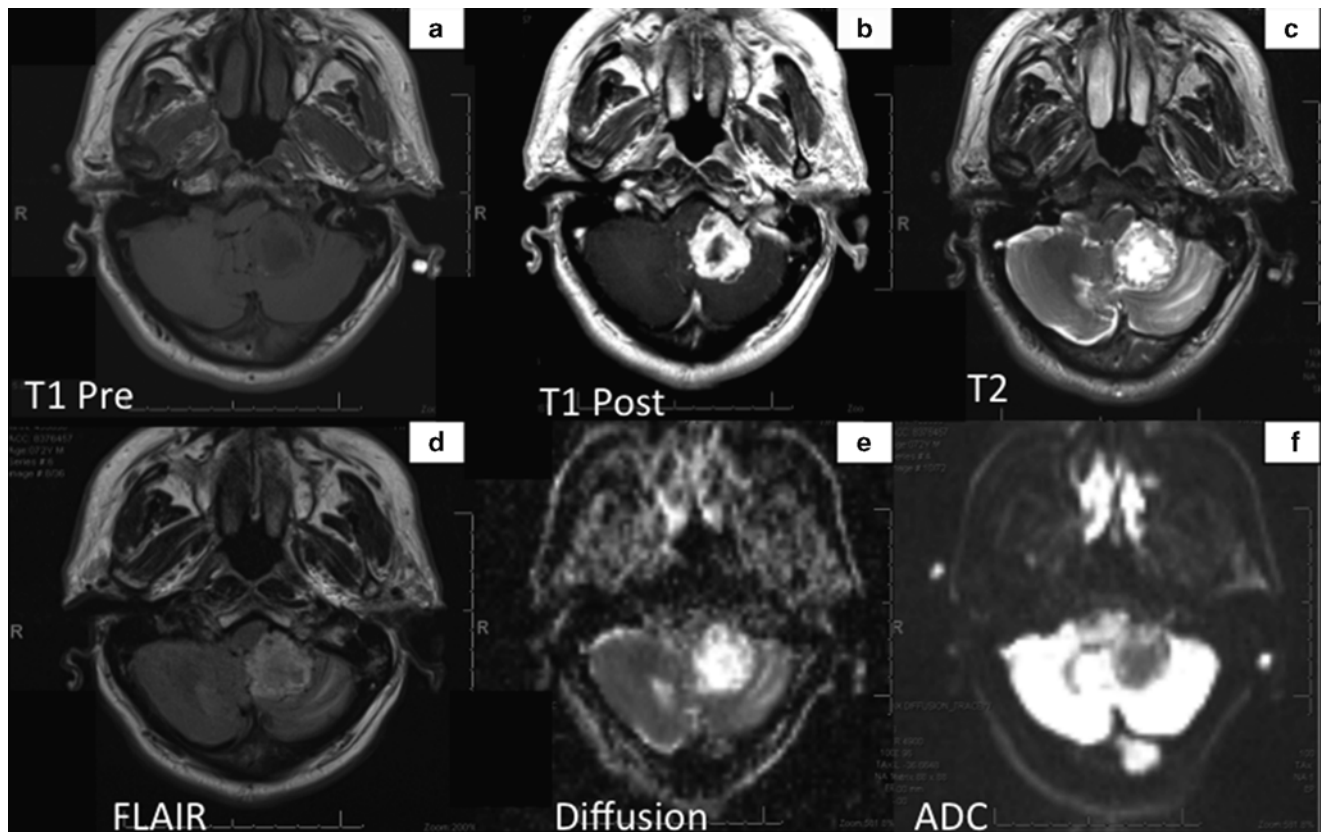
MRI shows the tumor that appears as an irregular thick-walled mass in the region of the left cerebellar tonsil, which enhances intensely with gadolinium (Panel b). Mass is predominantly T1 hypointense (panel a) but contains several areas of T2
